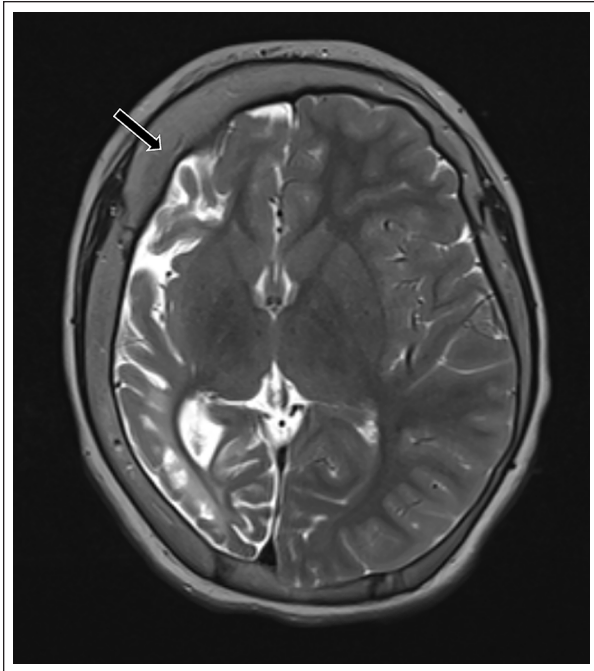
Axial T2 of MRI sequence demonstrating a calvarial thickening interesting the affected side (Black arrow).
